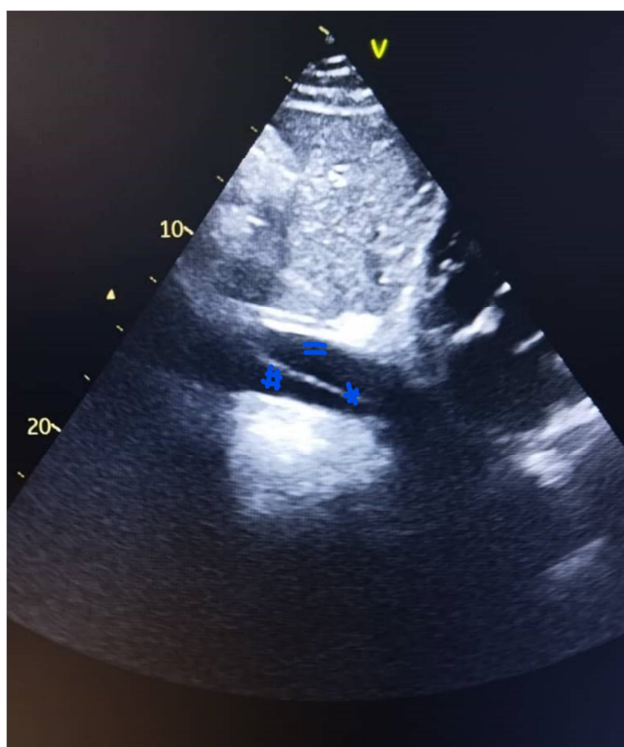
Two-dimensional transthoracic echocardiographic image in subcostal incidence showing the intimal flap (*) at the level of the abdominal aorta delimiting the true channel (#) from the false channel (=) in a patient with Type B Aortic Dissection managed at the CNHU-HKM of Cotonou between 2018 and 2023.
